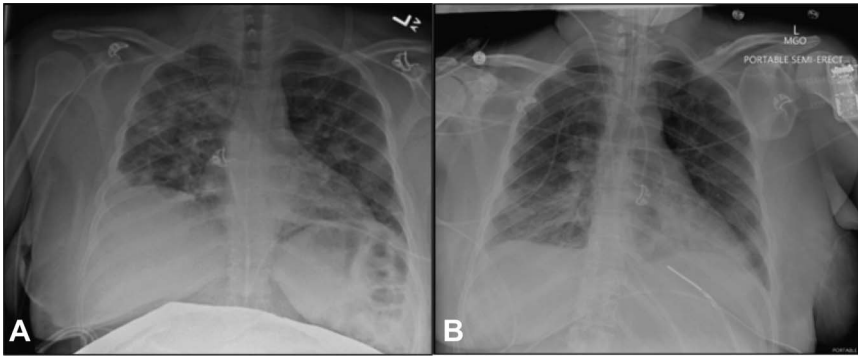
Maternal chest radiography. A. Imaging on admission showed multifocal consolidations and reduced lung volumes. B. Repeat imaging on postoperative day 3 showed improved lung volumes and decreasing bilateral opacities.
